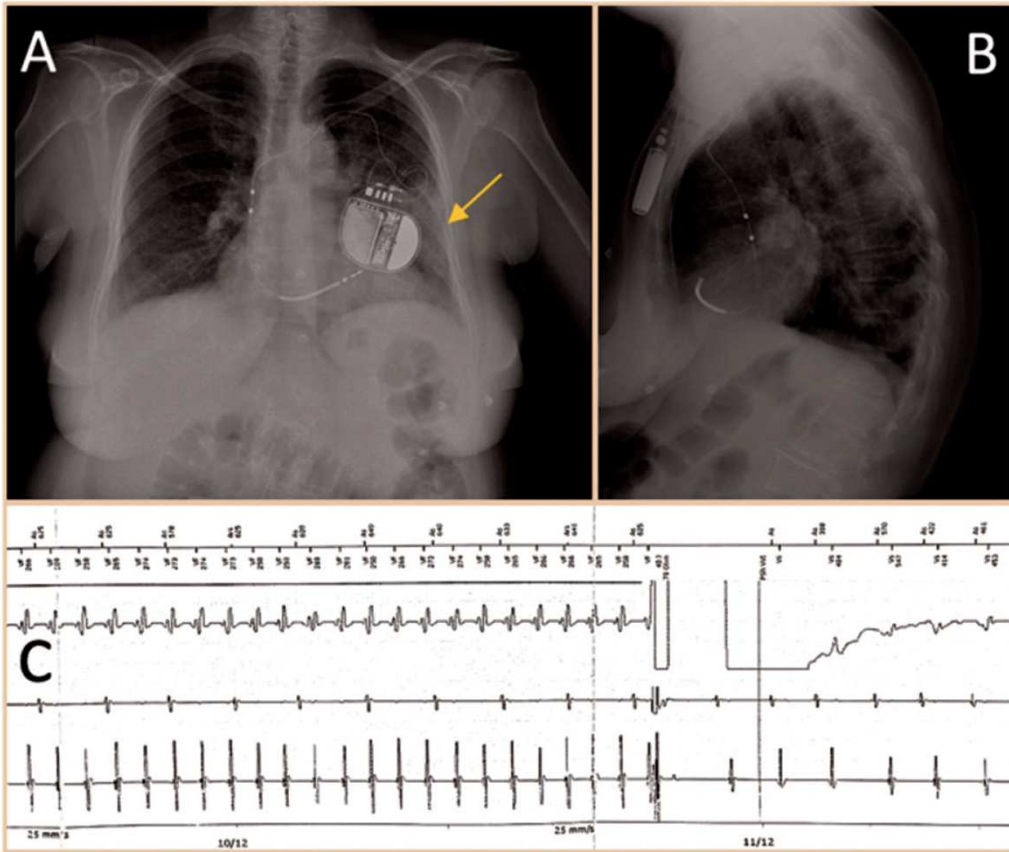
Chest radiograph with left pulmonary consolidation (arrow) in the left inferior lobe, suggestive for pneumonia. Anterior–posterior view (A) and lateral view (B). Electrogram with sustained ventricular tachycardia interrupted by DC shock (C).
